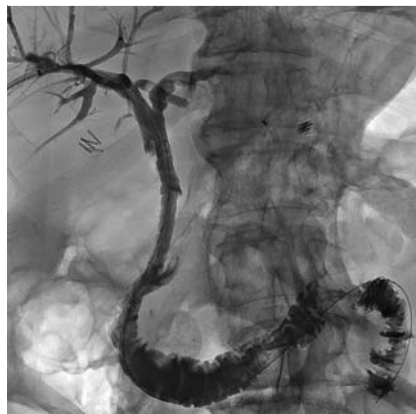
Final abdominal radiograph showing normal passage of contrast medium from the biliary tree into the afferent limb with no evidence of leakage.
